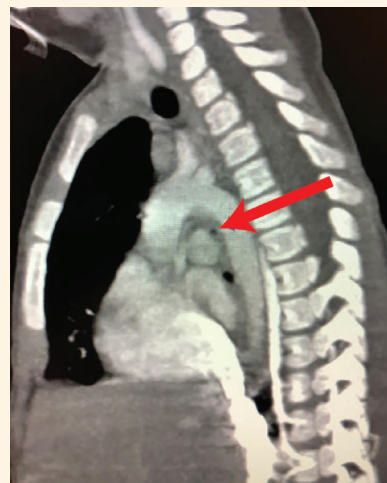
Sagittal reformatted computed tomography scan of the chest of a 16-month-old girl showing compression of the accessory tracheal bronchus (red arrow) between the anomalous right-sided aortic arch and pulmonary artery leading to luminal stenosis and bronchomalacia.
